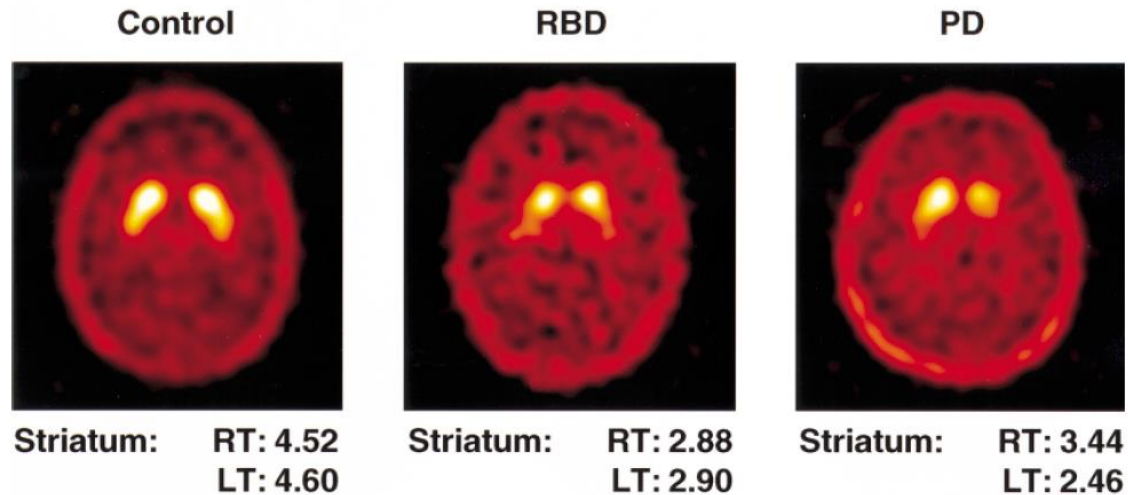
The [123I]IPT-SPECT of one patient with RBD, one patient with Parkinson's disease (Hoehn and Yahr stage I) and one control subject. Binding ratios are given below the [123I]IPT-SPECTs. Note the bilaterally reduced IPT binding ratio in the RBD patient, whereas in the Parkinson's disease patient the reduction is asymmetrical, being more pronounced contralateral to the symptomatic body side of the patient. RT = right; LT = left.
